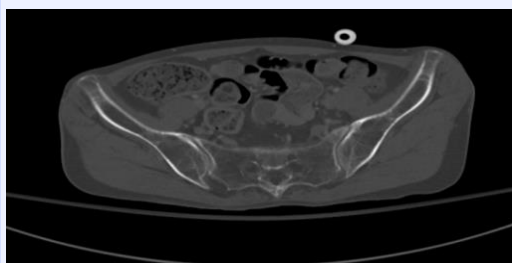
Pelvic Bone Computed Tomography(CT), No evidence of sacroiliitis (January 2, 2023)
